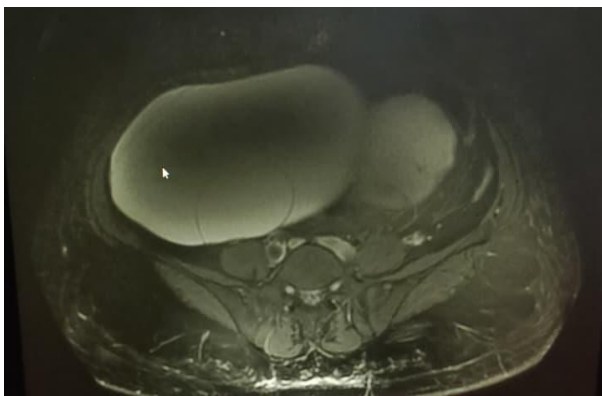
MRI depicting the thin-walled cystic mass with daughter cyst within.
